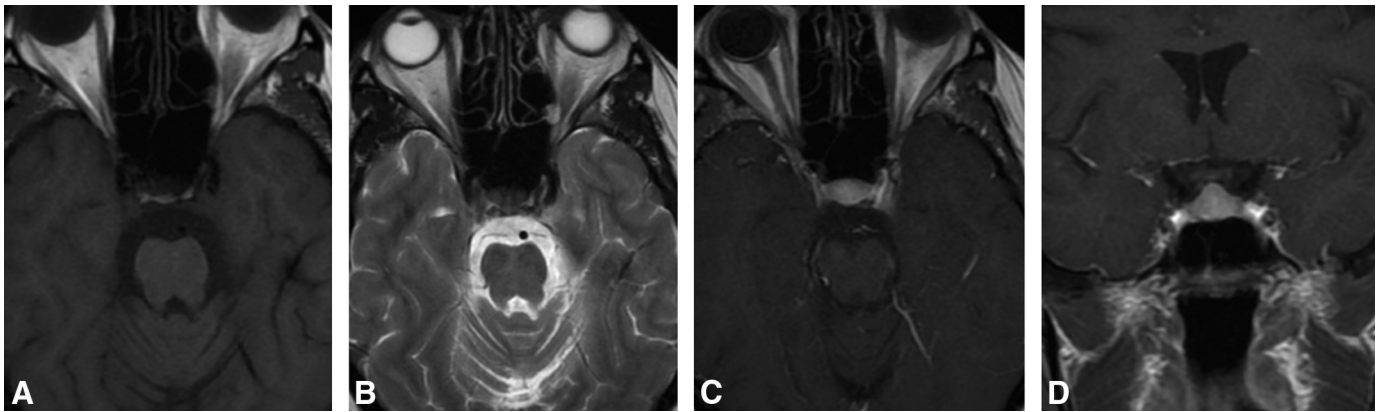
Sarcoid hypophysitis. Axial T1WI (A) and T2WI (B) and postgadolinium axial (C) and coronal T1WI (D) of a patient with hypophysitis. A 49-year-old woman with a history of progressive dizziness. MR imaging demonstrates an enlargement of the pituitary, with upward bulging into the suprasellar cistern, touching the optic chiasm; appearances may be the result of hypophysitis due to involvement by sarcoidosis.
